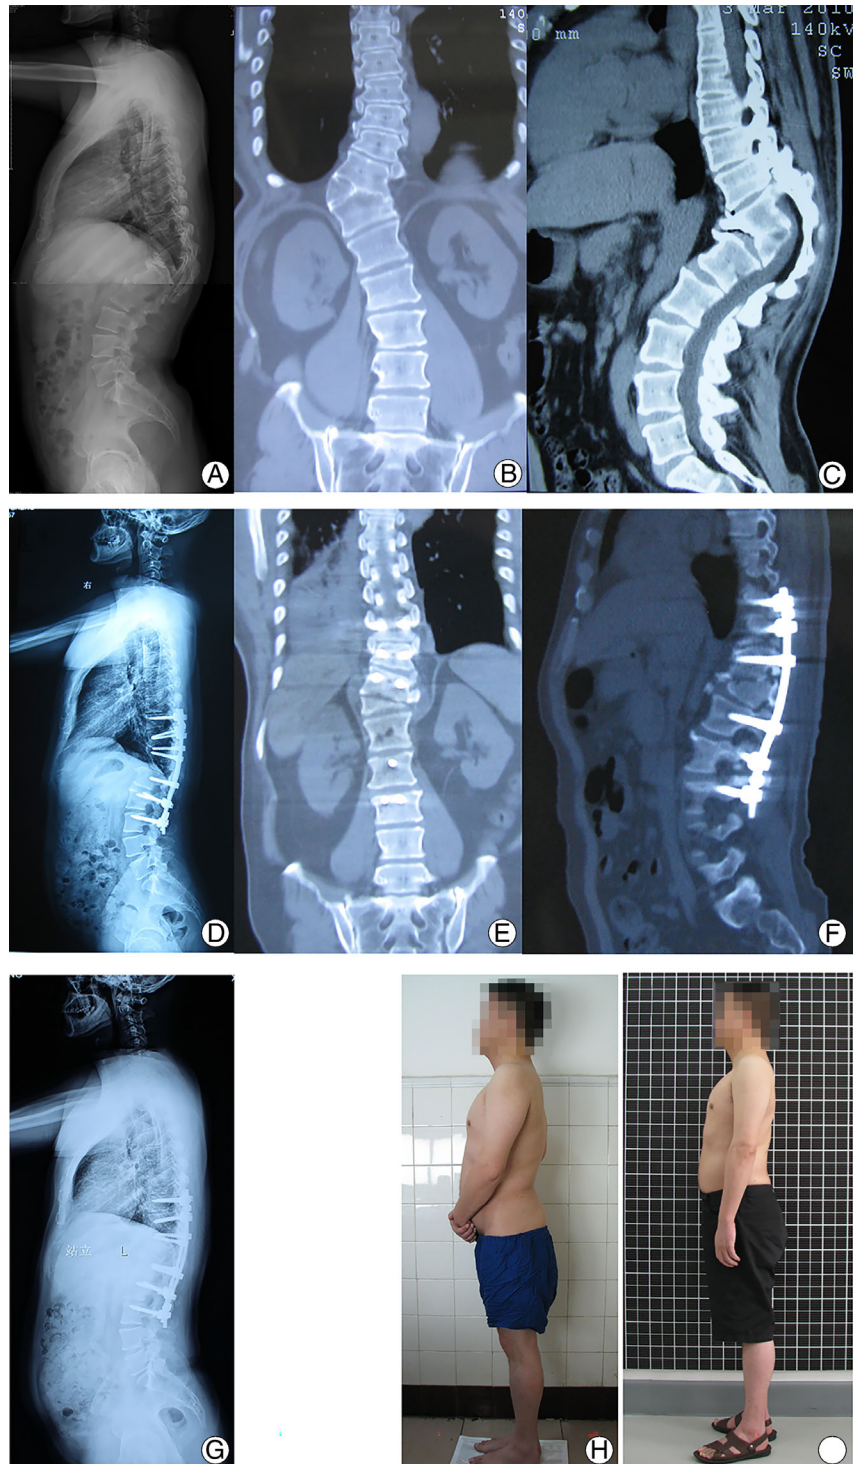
A 40–50-year-old case with T_{11–12} congenital spinal angular kyphosis. (A–C) Preoperative lateral X-ray and 3D CT scan showed a T_{11–12} congenital kyphosis, with a deformity angle of 80°. (D–F) Postoperative lateral X-ray and 3D CT scan showed DCVO at T_{11–12} complex, with a deformity angle of 23°. (G) Latest follow-up X-ray showed a deformity angle of 22.2°. (H, I) Preoperative and last follow-up clinical photos.
